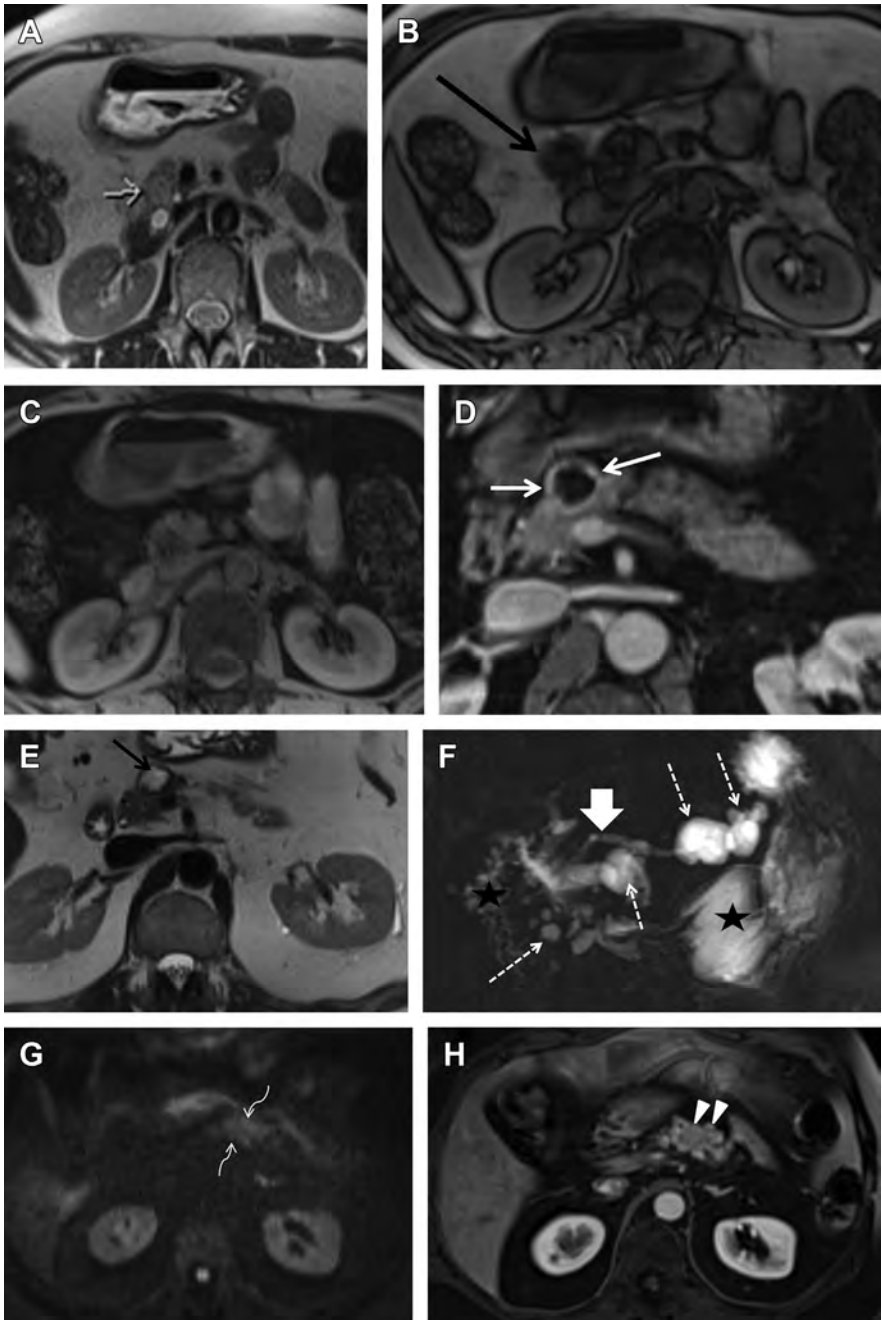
Axial T2-weighted image without fat suppression shows focal T2 hyperintense lesion (*arrow*) in the pancreatic head (A). Subcutaneous and mesenteric fat is also hyperintense on this image. On the axial T1-weighted opposed-phase image, the pancreatic head lesion shows blooming T2 hypointense signal (*arrow*) (B). Axial T1 gradient echo pre-contrast image with fat suppression shows that the pancreatic head lesion is hypointense compared with the background pancreas (C). Fat in the mesentery is also hypointense.
